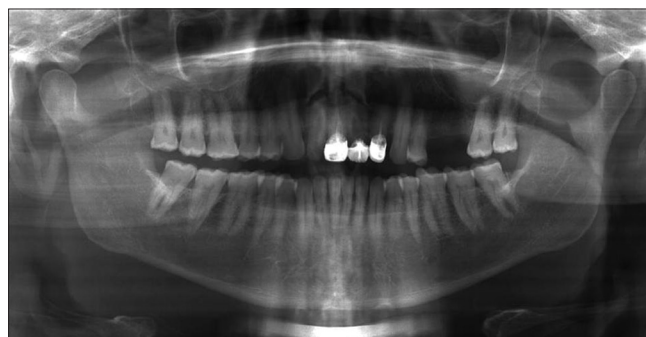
Orthopantomogram depicting ill-defined radiolucency in the periapical region of upper anterior teeth
